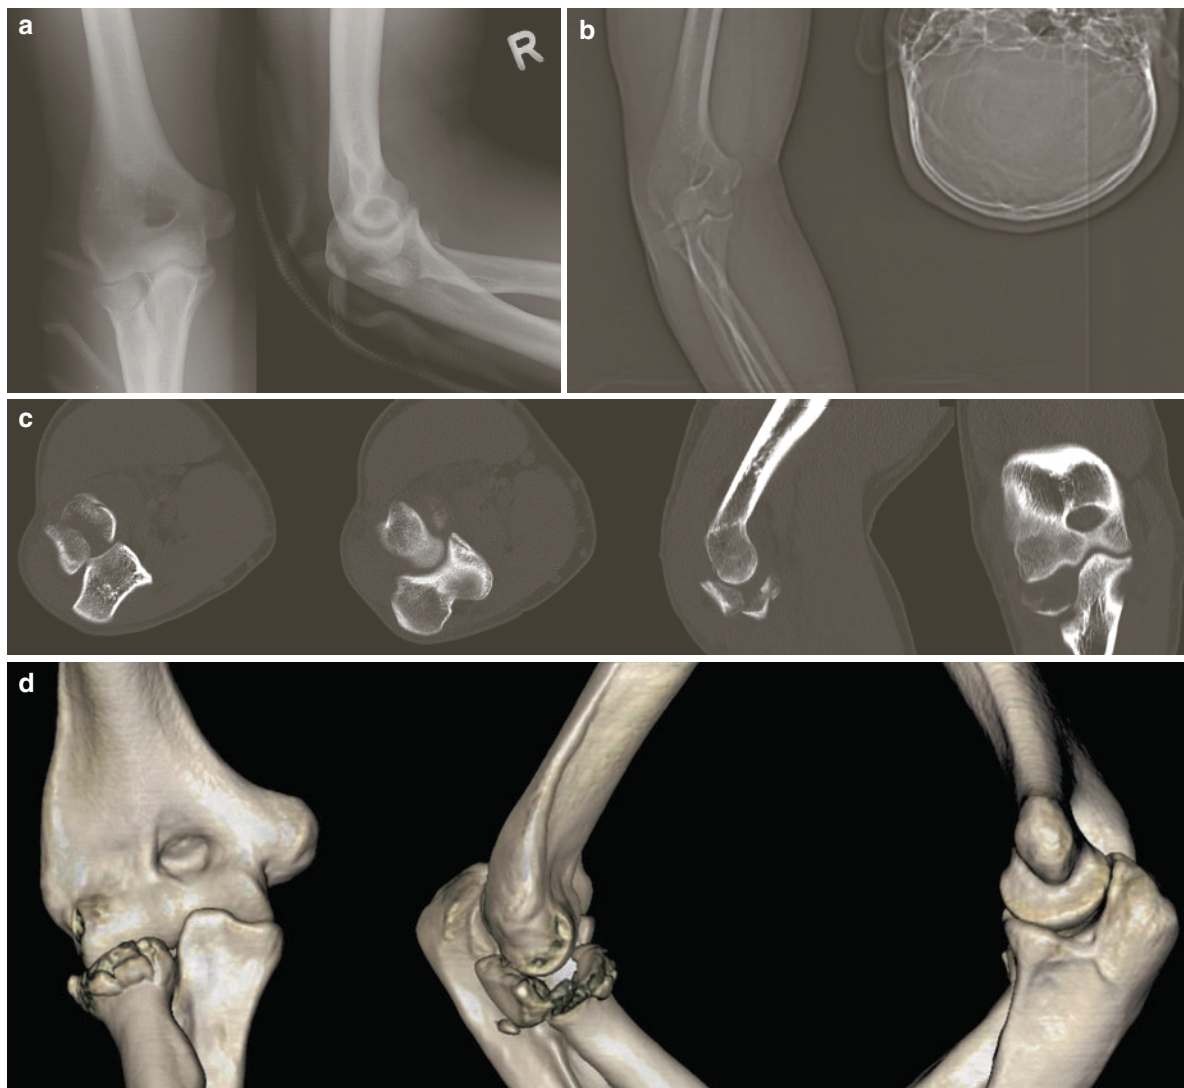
Fracture dislocation of the right elbow in a 35-year-old man: (a) lateral X-ray demonstrating a complex coronoid fracture; (b) sagittal CT reconstruction showing basal multi-fragmented coronoid fracture pattern. (c) 3-D CT reconstruction depicting two distinctive fragments, of which one is an antero-medial facet
